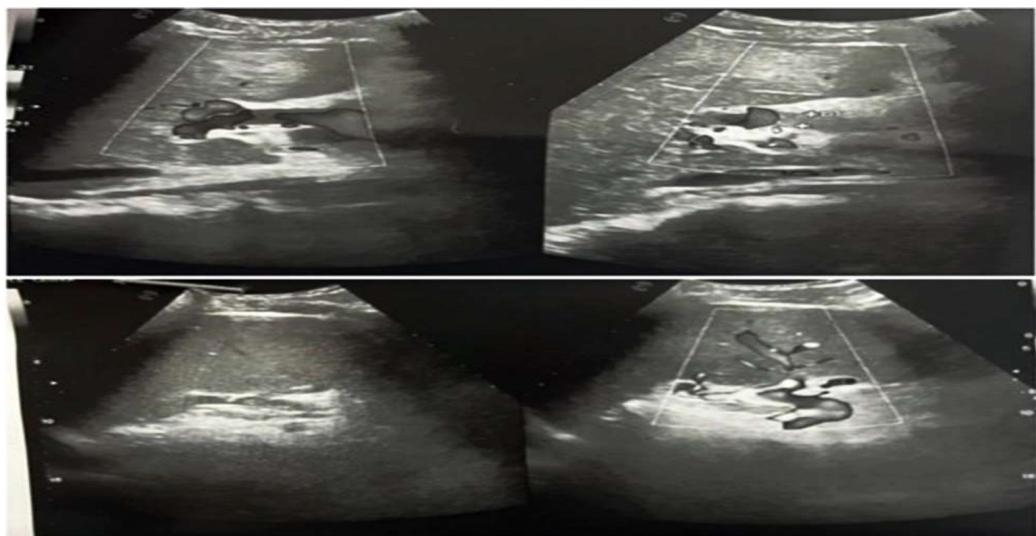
USG Doppler abdomen/hepatobiliary suggestive of Portal and Splenic Vein thrombosis
